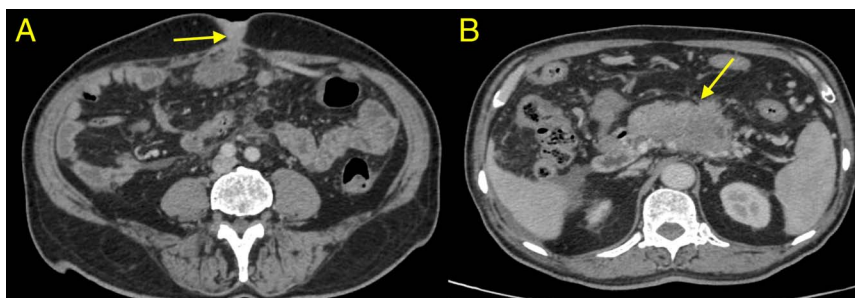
Computed tomography of the abdomen showing (A) Sister Mary Joseph nodule (arrows) and (B) a mass involving the body and tail of the pancreas (arrows).
